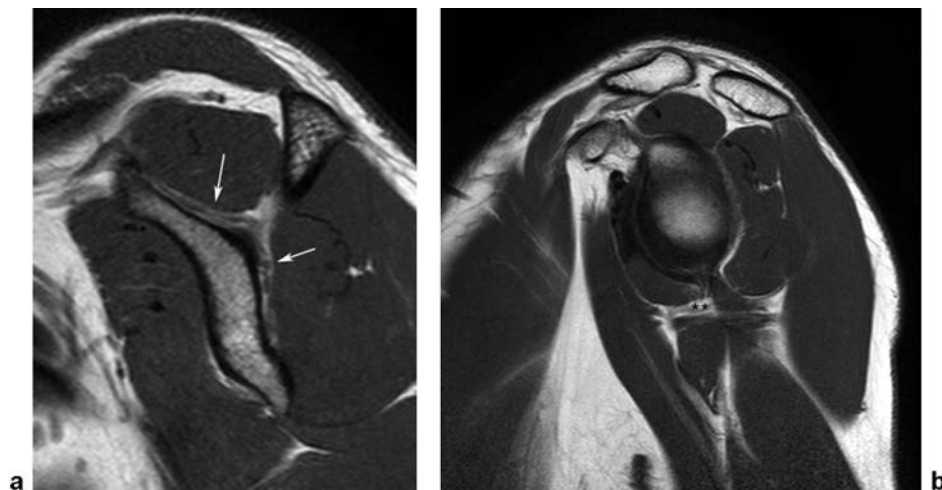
T1-weighted image in the sagittal plane. (a) Suprascapular nerve (arrows). (b) Axillary nerve (asterisk).
